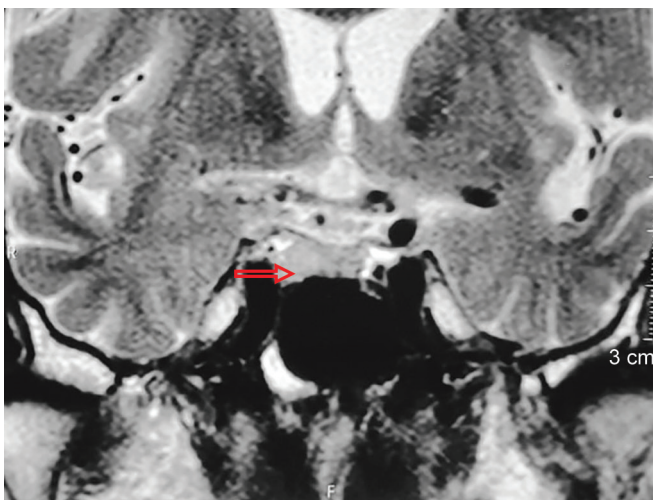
MRI brain showing asymmetrical enlargement of right half of pituitary measuring 8 mm in maximum length with few cystic changes
